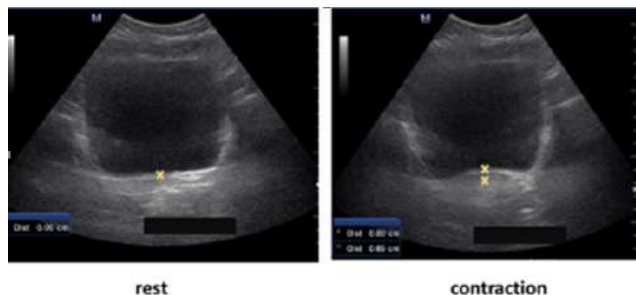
Pelvic Floor Muscle Assessment via Transabdominal Ultrasound
